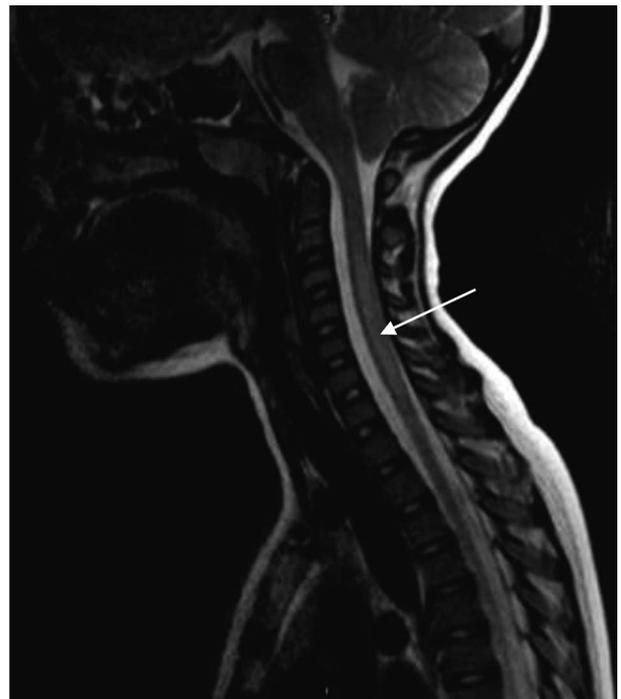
MRI cervical spine in a child diagnosed with AFM, demonstrating an ill-defined T2 hyperintensity spanning the cervical spine with involvement of the gray matter and to a lesser extent, white matter.
